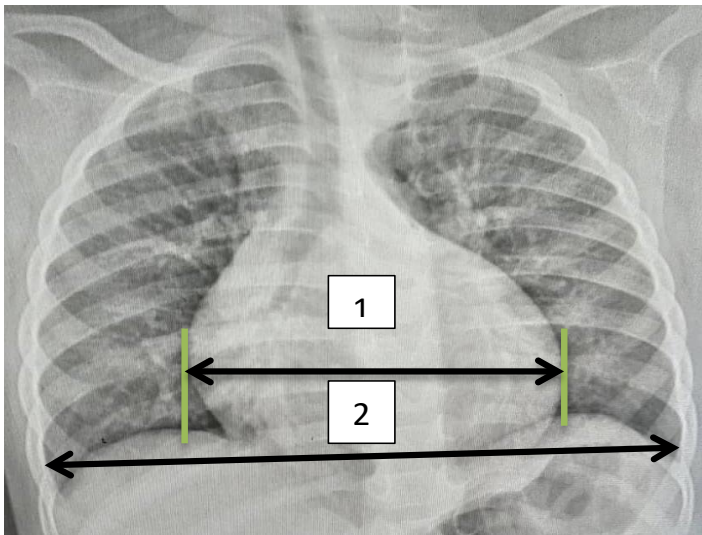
Frontal chest x-ray showing the technique for measuring cardiac and thoracic diameters.
